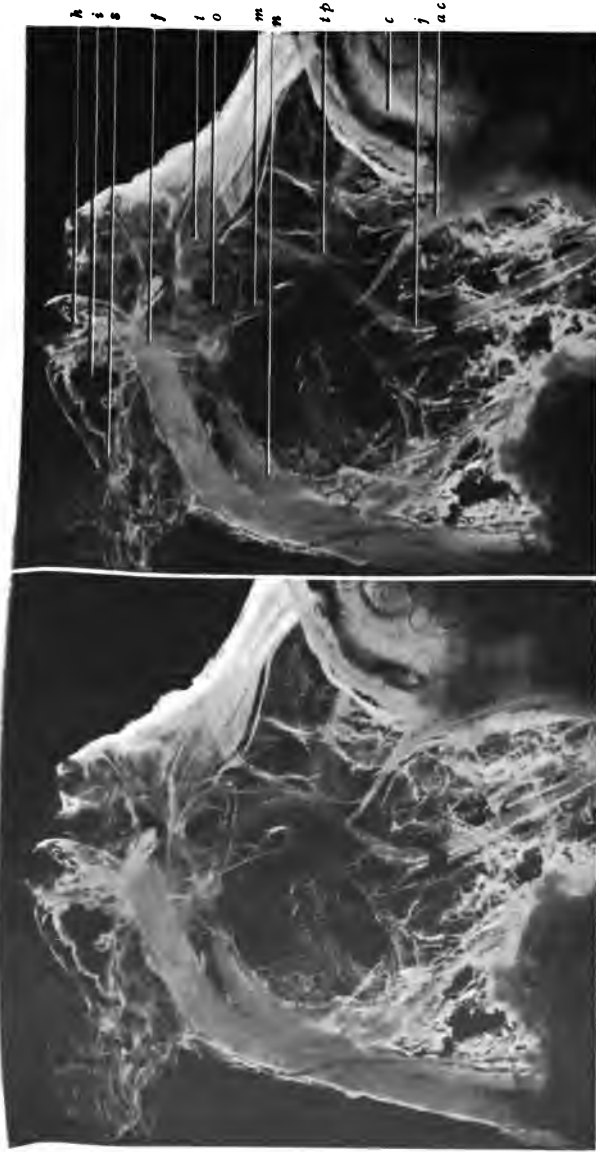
THE SOFT PARTS OF THE TYMPANUM AND ADJACENT REGIONS: VIEWED FROM THE INNER ASPECT AND BEHIND. $\times 3\frac{1}{2}$. (Prepared and photographed by the Author.)
